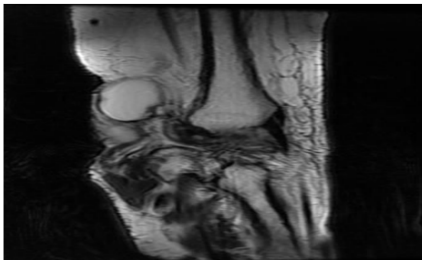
T2-weighted Axial View of the Left Wrist. A Fluid-filled Cystic Lesion in a Close Proximity to the Radius
